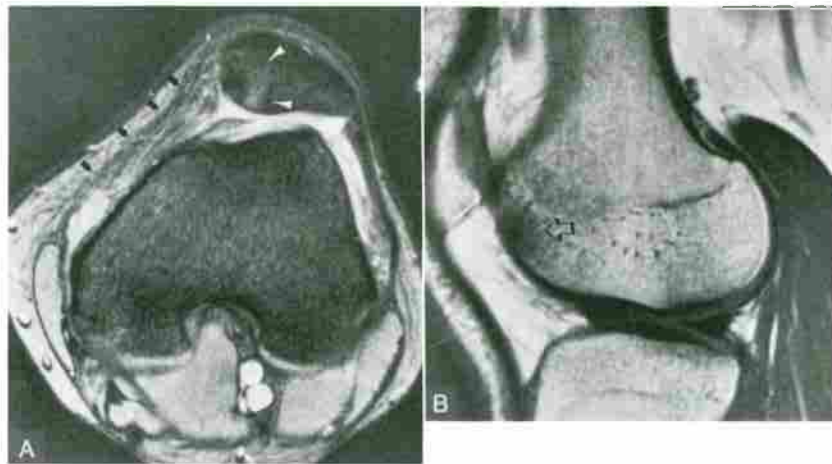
Sequelae of patellar dislocation. A, Axial gradient-echo (TR/TE, 578/18; angle, 30 degrees) image demonstrates a contusion of the medial facet of the patella (white arrowheads), resulting from the impaction against the lateral femoral condyle. The medial retinaculum (arrows) shows diffuse high-signal-intensity separating fibers representing partial tears. Also note the lateral subluxation of the patella. B, Sagittal T1-weighted (TR/TE, 430/20) image through the lateral joint compartment shows the bone contusion of the anterior aspect of the lateral femoral condyle (open arrow).
